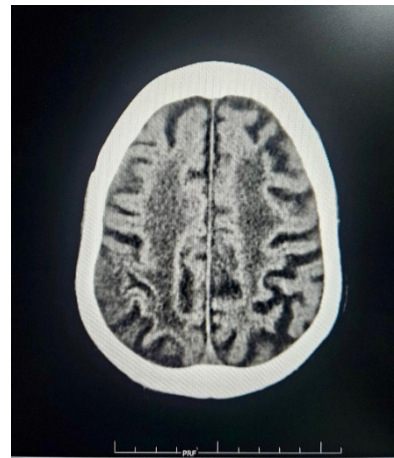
Magnetic resonance imaging of a man patient aged 78. On T2/FLAIR imaging, extensive periventricular hyperintense regions were also observed, which may indicate small vessel alterations. They describe gliotic alterations in the left upper frontal lobe.
